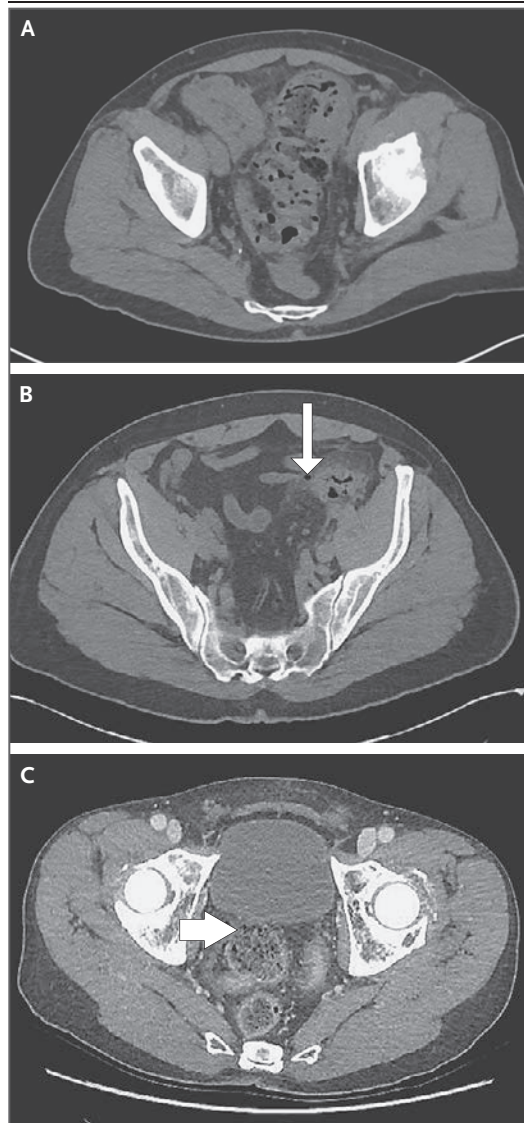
CT Images of the Colon in Patients with Diverticulitis.
